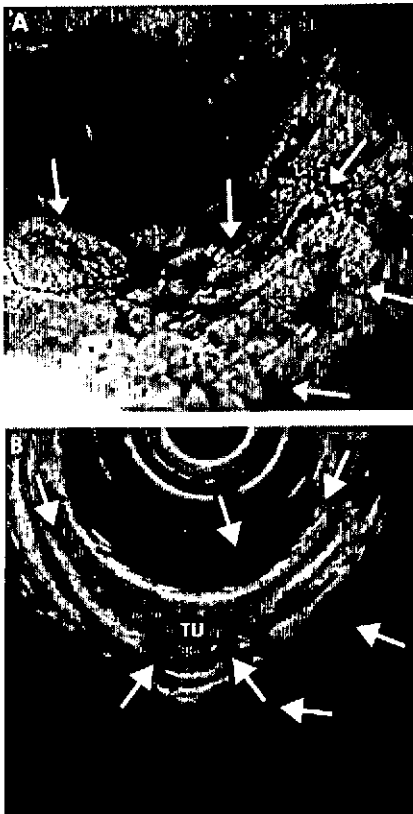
Barrett cancer in stage T1sm; endoscopic view of a large flat tumour with the margins indicated by arrows (A). Endoscopic ultrasonography shows a focal echo poor thickening (TU) of the mucosa with thinned submucosal layer (arrows) due to tumour infiltration (B).
